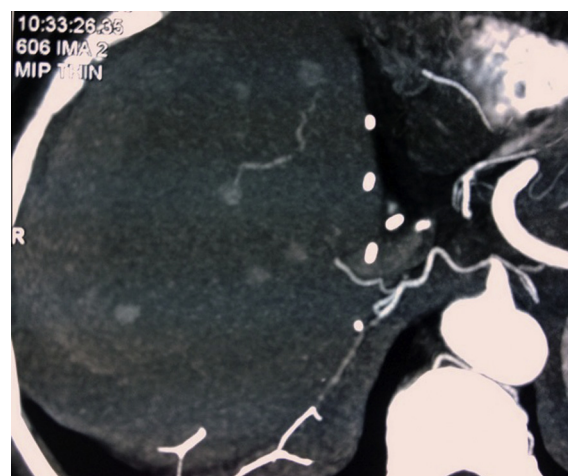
Sixty-one year old male recipient 1 year after LDLT for liver cirrhosis and HCC. Axial CT image showing multiple enhancing recurrent HCC lesions.
